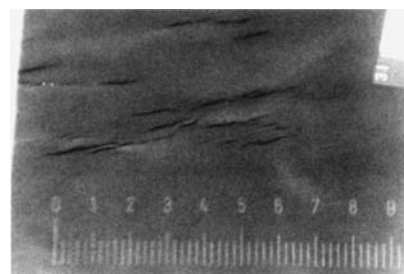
Radiograph of lead apron with multiple cracks. Scale is in centimeters.
